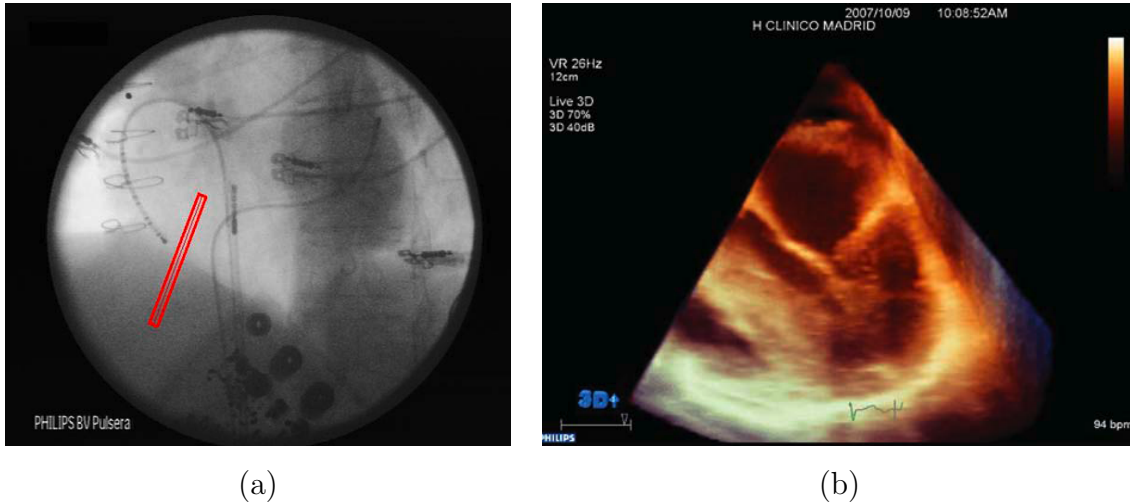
(a): A manually delimited region of interest for tracking diaphragm motion in live fluoroscopic X-ray images [113]; (b): 3D echocardiography evaluation of the mitral valve [229].
